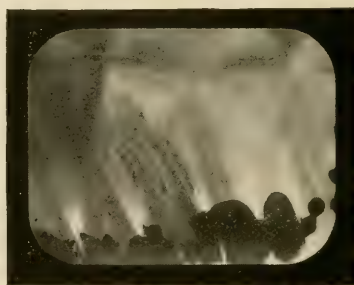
Angle of X-rays, arrow C, Fig. 440.
